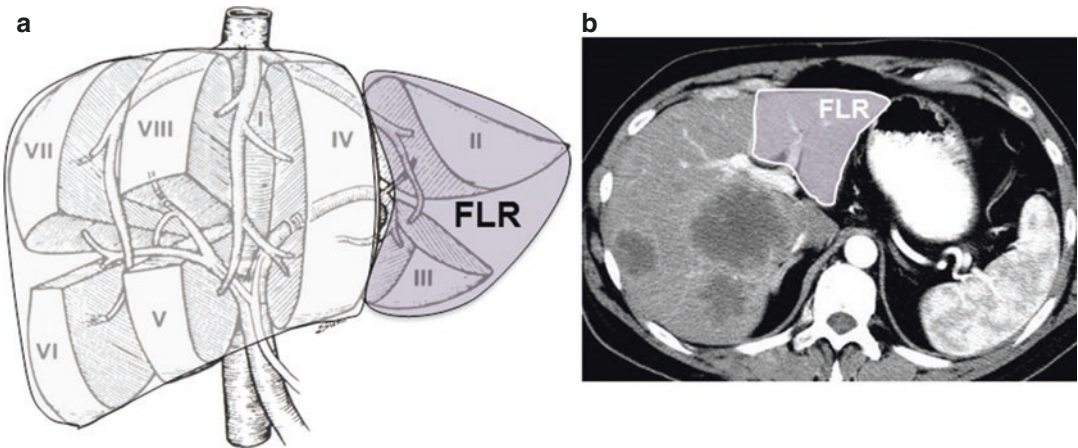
Scheme (a) and CT scan (b) of the future liver remnant (FLR) in a patient undergoing evaluation for an extended right hepatectomy of segment 5–8 + segment 4 and 1. Segments 2 and 3 represent the FLR
